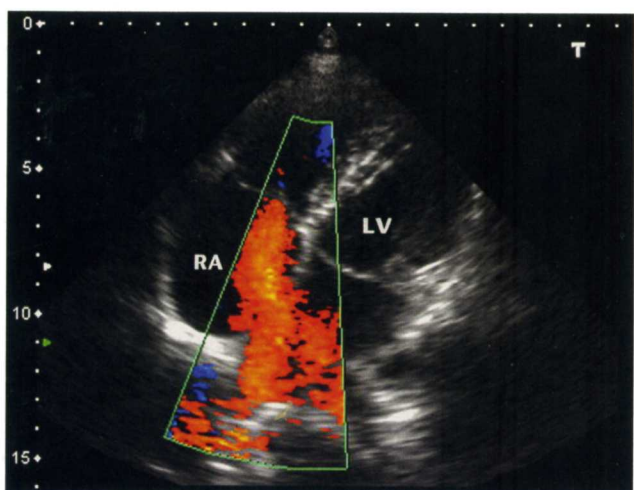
Case 2: Parasternal long-axis ultrasound view. (Courtesy of Hennepin County Medical Center)
